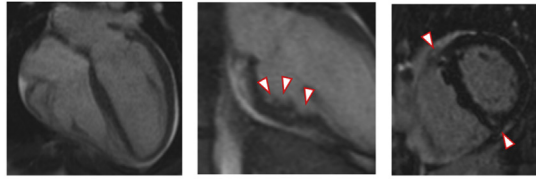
Cardiac Magnetic Resonance Images
